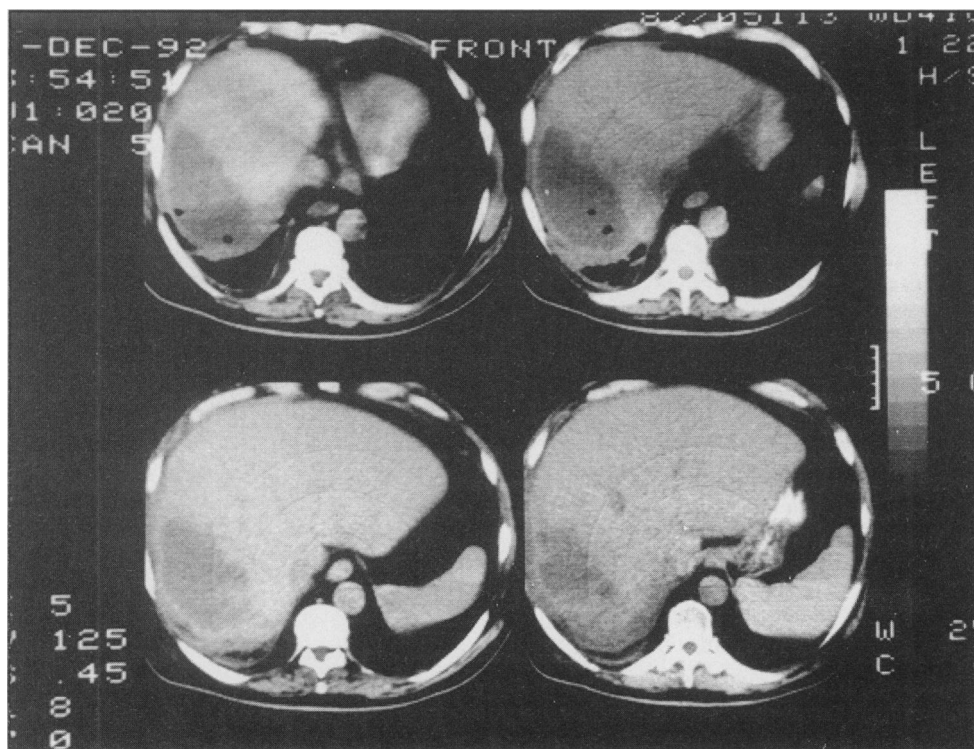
Post-operative CT scan after resection and drainage showing fluid-filled cavity in right hepatic lobe.
